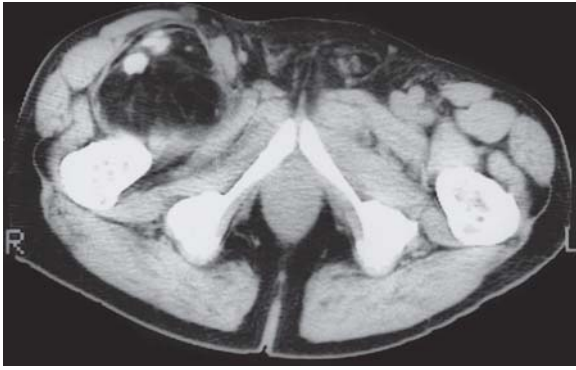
Lipoma of the right thigh in a 51-year-old man. Computed tomography. Hypodense mass arising in the right adductor compartment containing fibromuscular septa and several foci of ossification
